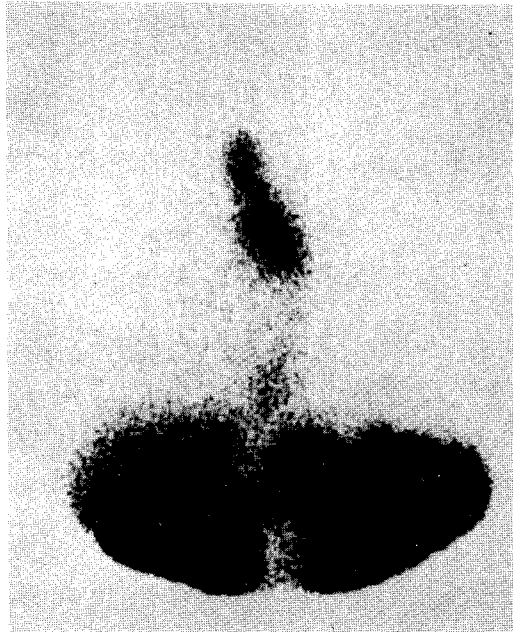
Demonstration of bile reflux by hepatobiliary scintigraphy using ^{99m}Tc -diethyl IDA.
